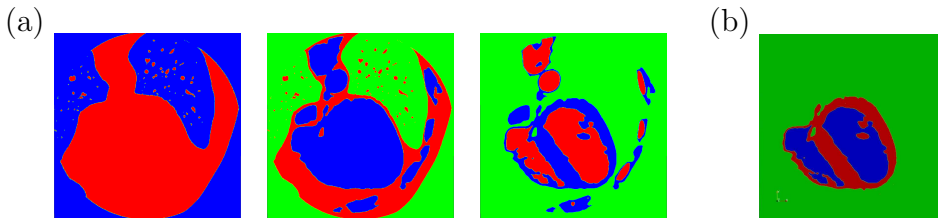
Segmentation process. (a) Iterative segmentation of the CT scan slice. From left to right: lungs boundary, epicardial and endocardial identifications. (b) Final image of the ventricle slice.
